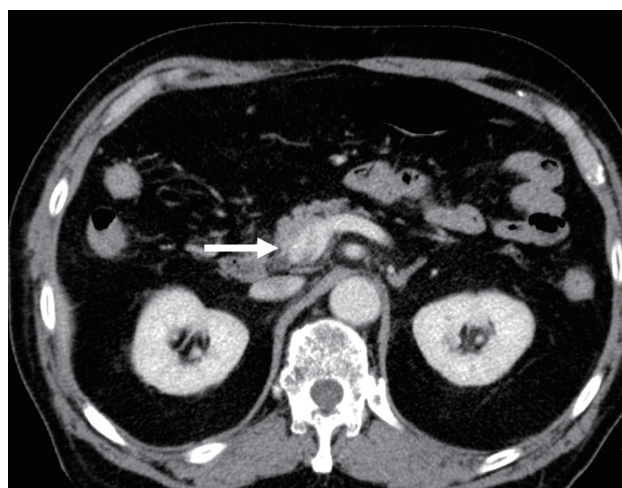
Follow-up abdominal CT at day 10 after IR and surgery shows only a small amount of remnant thrombus in the PV and SMV (arrow). CT, computed tomography; IR, interventional radiology; PV, portal vein; SMV, superior mesenteric vein.
